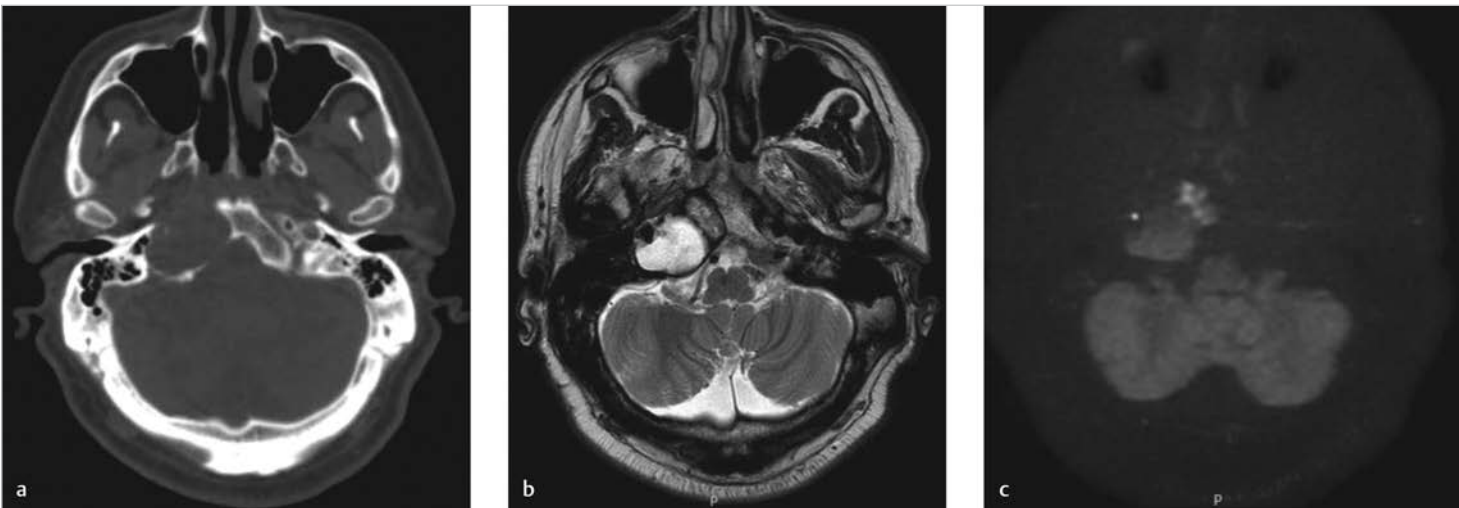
A case of right petrous apex cholesterol granuloma. (a) The CT shows expansive growth of a round-shaped lesion in the right petrous apex. (b) The lesion shows very high-signal intensity in T1 image. (c) In contrast to cholesteatoma, the diffusion-weighted image demonstrated low signal in the lesion. The high signal medially to the granuloma does not mean coexistence of cholesteatoma, and probably means some pathological change in bone marrow (see also ► Fig. 11.15–2).
